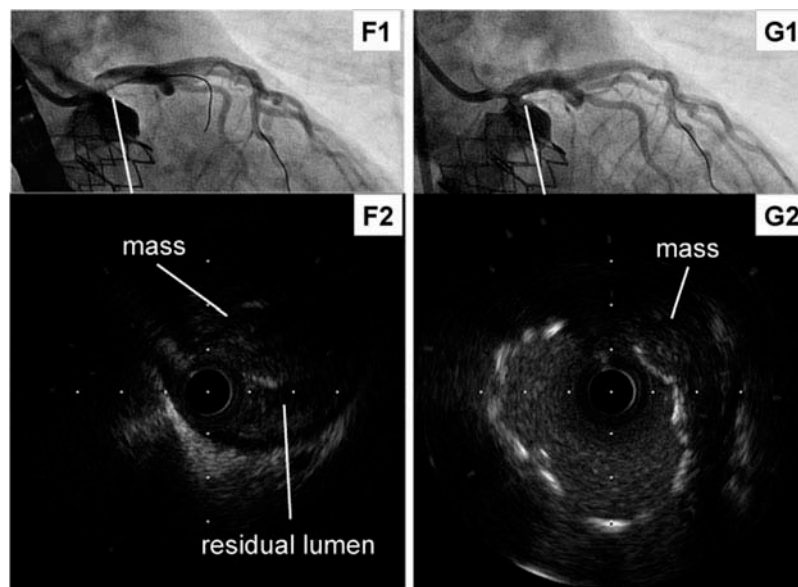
F1: Coronary angiogram after rescue balloon angioplasty; F2: Intravascular ultrasound after rescue balloon angioplasty; G1: Final coronary angiogram after drug-eluting stent implantation; G2: Final intravascular ultrasound after drug-eluting stent implantation.
